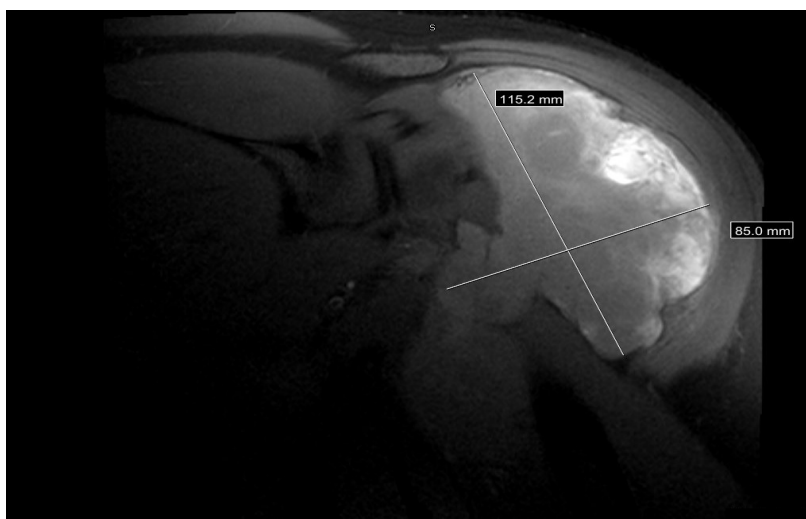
MRI of left arm showing large heterogenous soft tissue mass about the proximal humerus without evidence of bony involvement.
